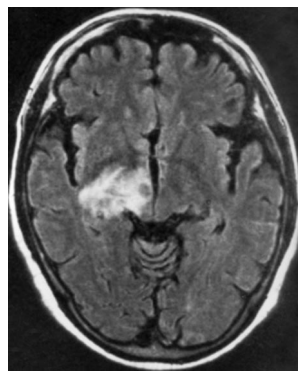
Patient 2. Axial magnetic resonance imaging scan, demonstrating venous infarction in the right thalamus and midbrain.
